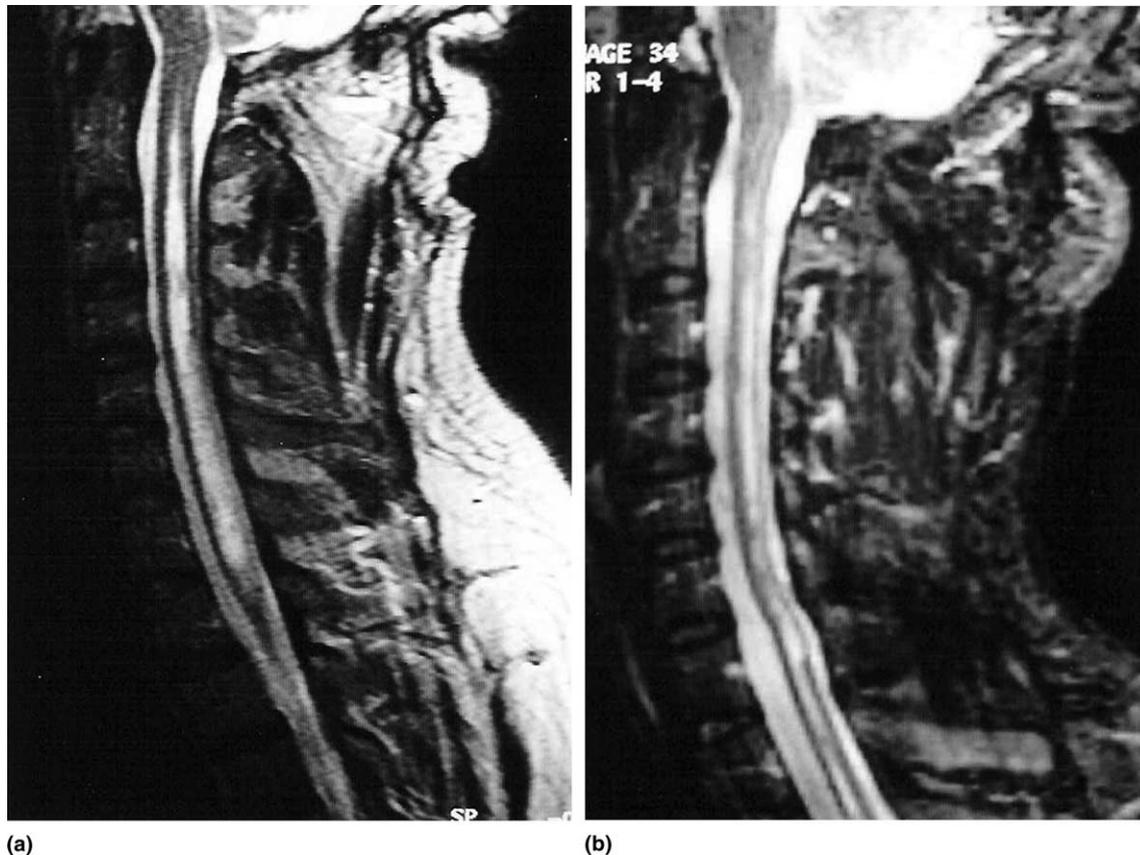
Sagittal T2-weighted MRI of the spine before (a) and one month after (b) surgery showing improvement of the syrinx after posterior fossa decompression, C1 laminectomy and syringo-subarachnoid shunting.
